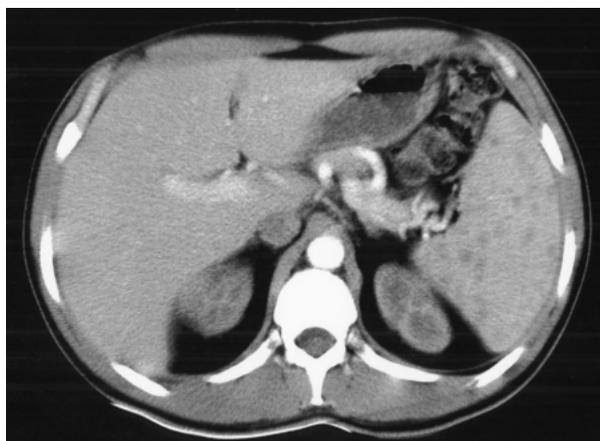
Computed tomography scan of the abdomen of the case patient reveals splenomegaly with multiple punctate lesions.
